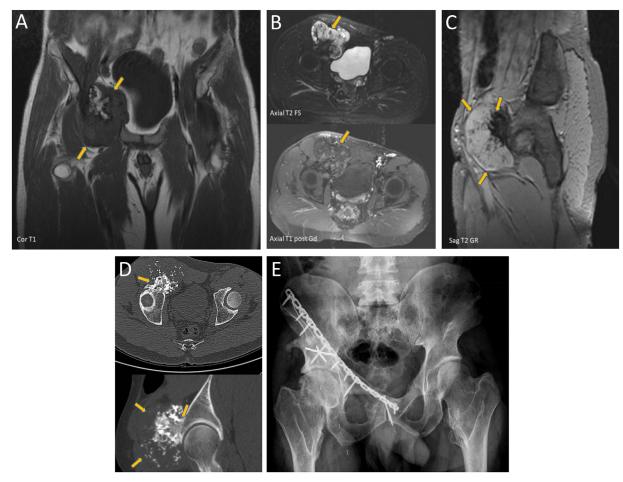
T1WI (A), FS T2WI and contrast enhanced FS T1WI (B), GRE T2WI (C), and CT (D) images show multiple osteochondromas affecting both iliac bones, sacrum, ilio-pubic ramus and both femoral necks and diaphysis. There is an expansive lytic lesion in the right puboacetabular junction with thick cartilaginous cap (>1.5cm) that suggests neoformative transformation (arrows in A, B, C, D). Radiograph after surgery where chondrosarcoma was confirmed (E). (Color version of figure is available online.)
